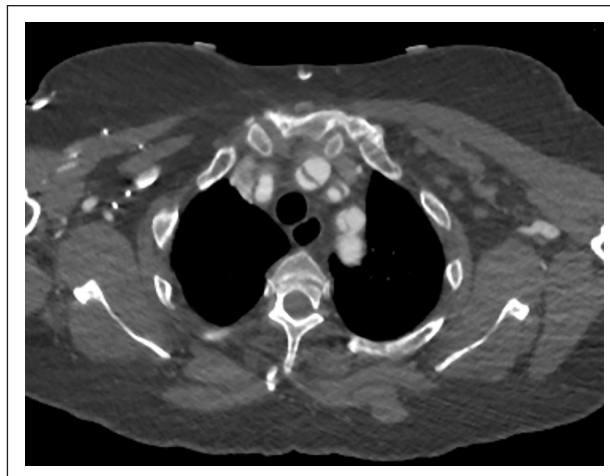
CTA axial section showing extension of the dissection flap to involve the common carotid artery, leading to the right MCA infarct due to occlusion of the right common carotid artery.
